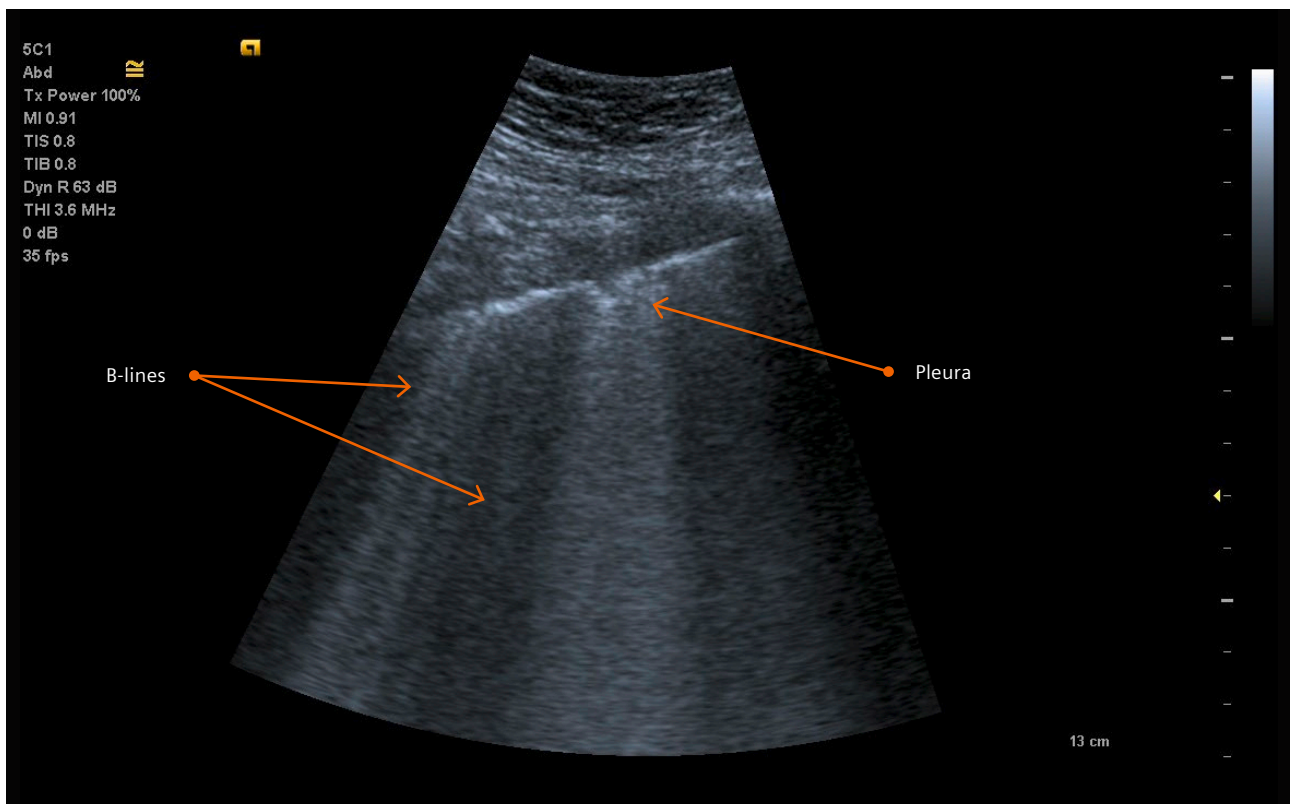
COVID-19 pneumonia. Follow-up examination in the ICU using a curved transducer. Ultrasound findings including pleural thickening and irregularity. Additionally, consolidations of the lung with B-lines are detected.
